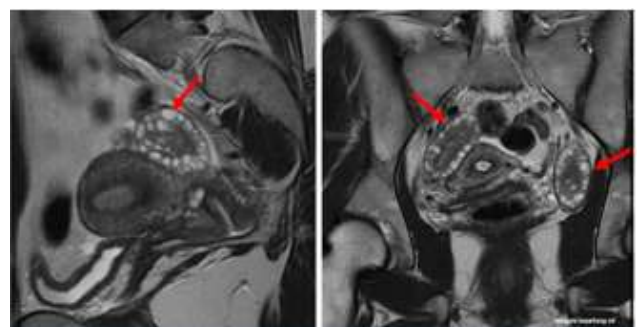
Display of MRI examination on PCOS [21]
